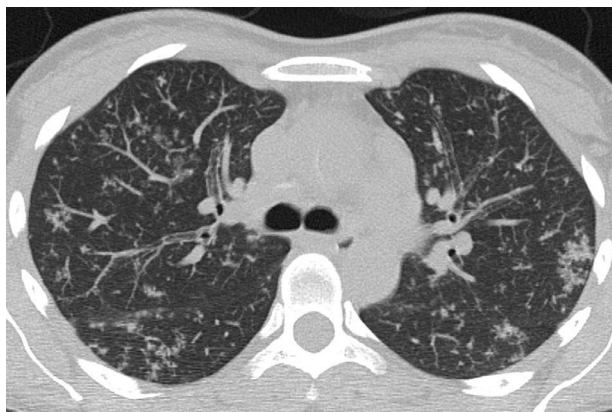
Atypical CT imaging features for COVID-19 pneumonia. Axial unenhanced chest CT image of the lungs in a 37-year-old control patient showing tree-in-bud opacities and centrilobular nodules, caused by active tuberculosis.
